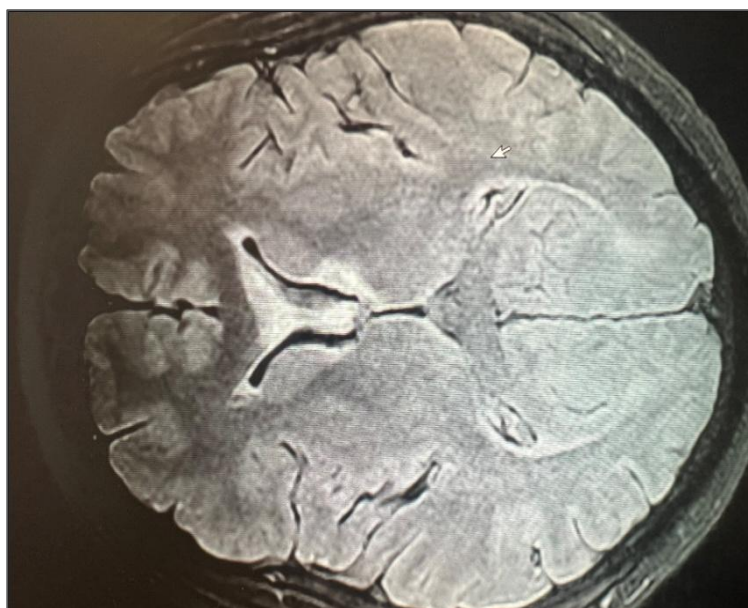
MRI scan of the head (cross-section of the brain) with well-demarcated areas of ventricle III.
